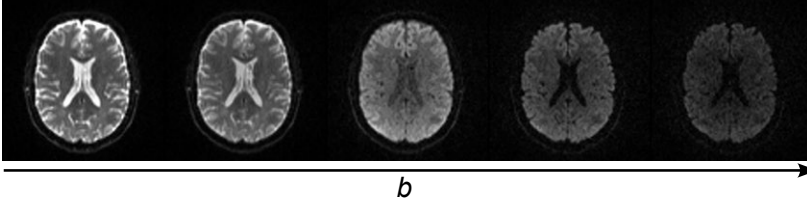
Diffusion-weighted MR images for increasing diffusion weighting as quantified by the b-value. As b increases, more of the signal is attenuated, as a manifestation of the magnetisation decay induced by the diffusion process. This attenuation naturally results in a lower signal-to-noise ratio as b increases.
